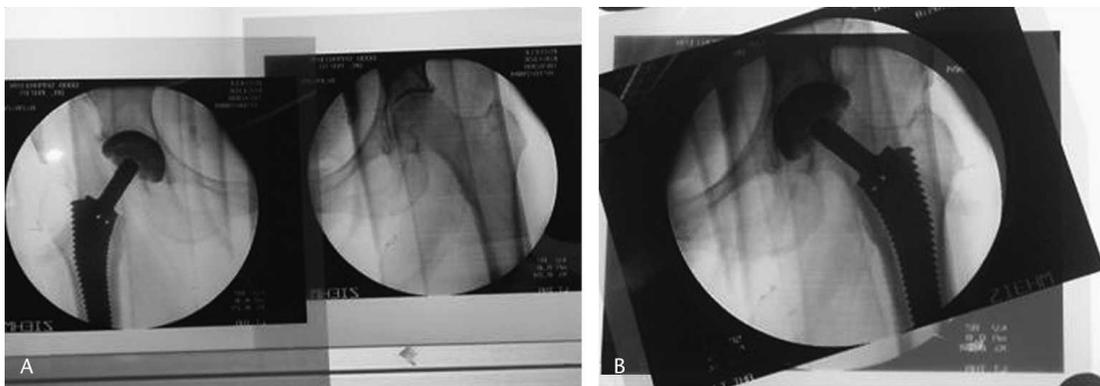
The image intensifier is used to obtain an image of the unaffected hip. An image is taken of the trial components in the reduced position, and the two images are superimposed. The radiographic landmarks of the pelvis are lined up and the landmarks of the femur are compared to verify correct length and offset.
